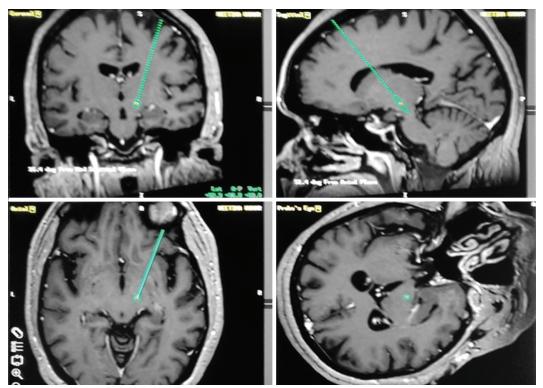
STN targeting, trajectory and entry point selection at computer planning station from preoperative DBS protocol MRI-right side
